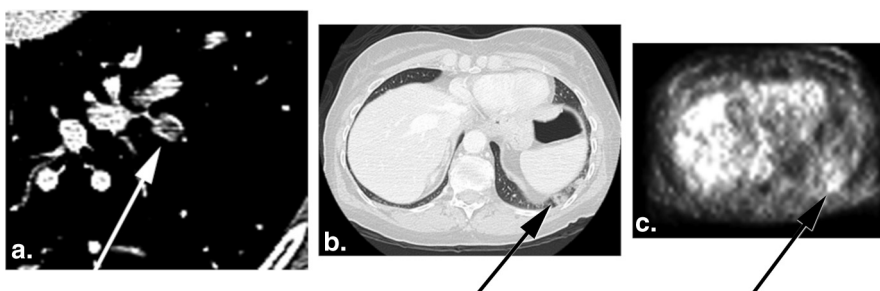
Example of peripheral pulmonary infarction with associated FDG avidity. A 61-year-old woman with history of breast cancer. Contrast-enhanced computed tomography demonstrates a segmental left lower lobe pulmonary embolism (a) and a small left lower lobe pulmonary infarction (b). The associated PET demonstrates an incomplete rim of FDG avidity surrounding the area of the infarction (c). FDG, fluorodeoxyglucose; PET, positron emission tomography.
